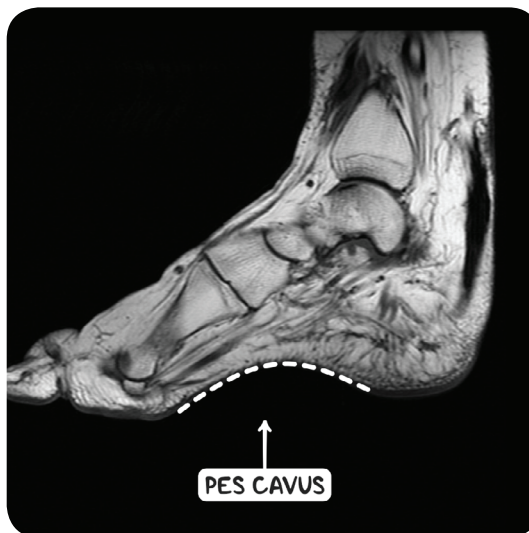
An MRI scan of the foot of an individual with Charcot-Marie-Tooth disease. There is wasting of the plantar muscles and prominent pes cavus as well as a hammer irregularity of the great toe.
